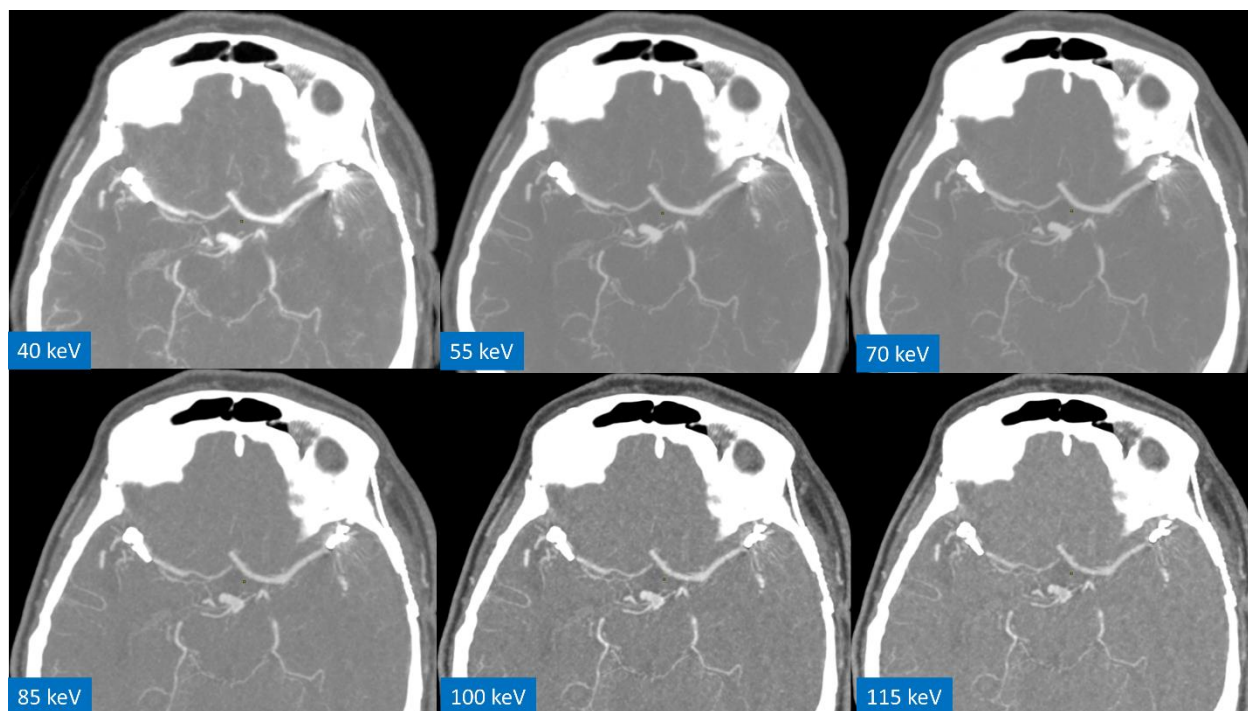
Cerebral imaging in a patient with bilateral intracranial aneurysm clipping causing beam hardening artifacts. The CTA was acquired on a fast kV-switching DECT system and reconstructed as VMI at different energy levels. The strong beam hardening artifacts hampering image analysis on the 40 keV VMI increasingly vanish with higher VMI energies.
